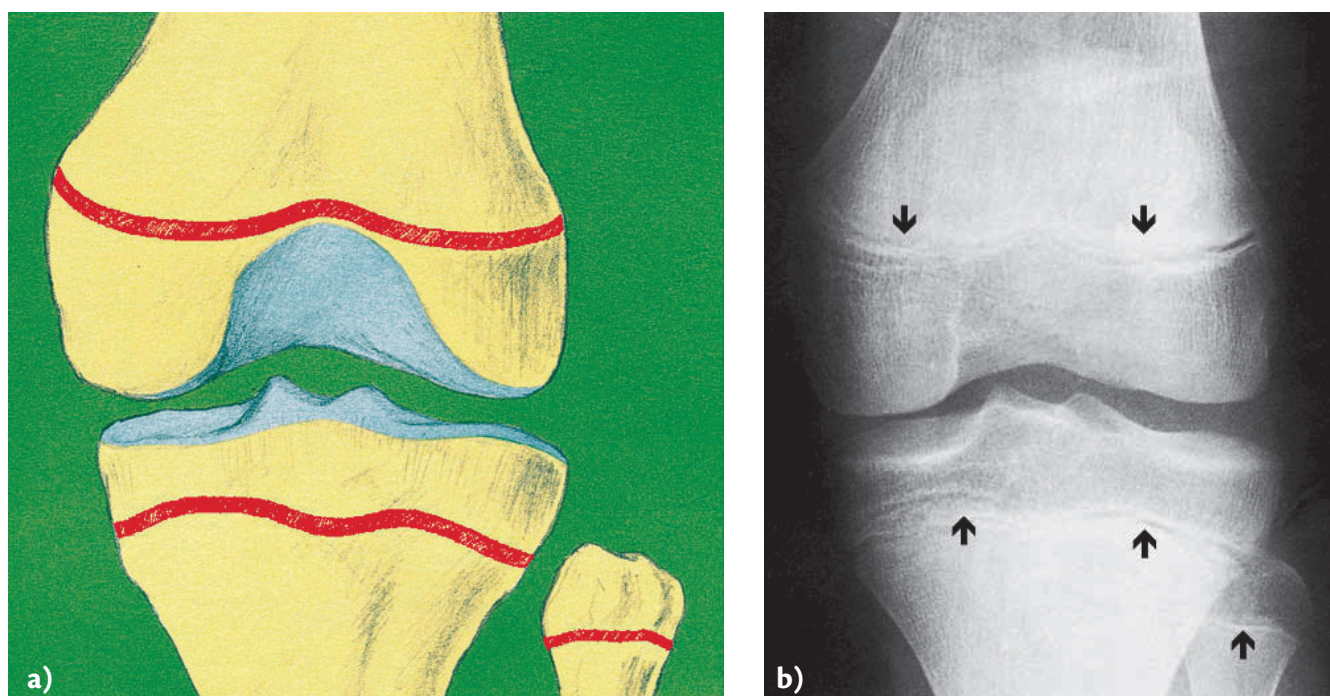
Growth zones. a) Growth zones in the distal/lower part of femur (thigh bone) and in the proximal/upper part of tibia (lower leg), where most growth in the lower extremities occurs; b) X-ray of the growth zones around the knee joint, i.e. in femur, tibia and fibula.
